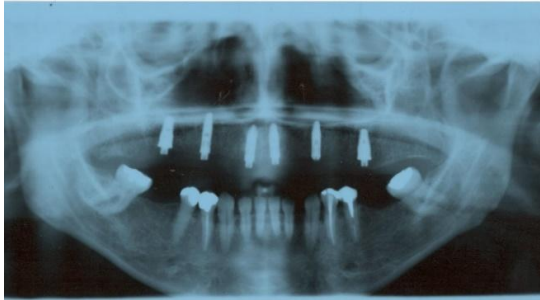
Panoramic radiograph after the osseointegration period
